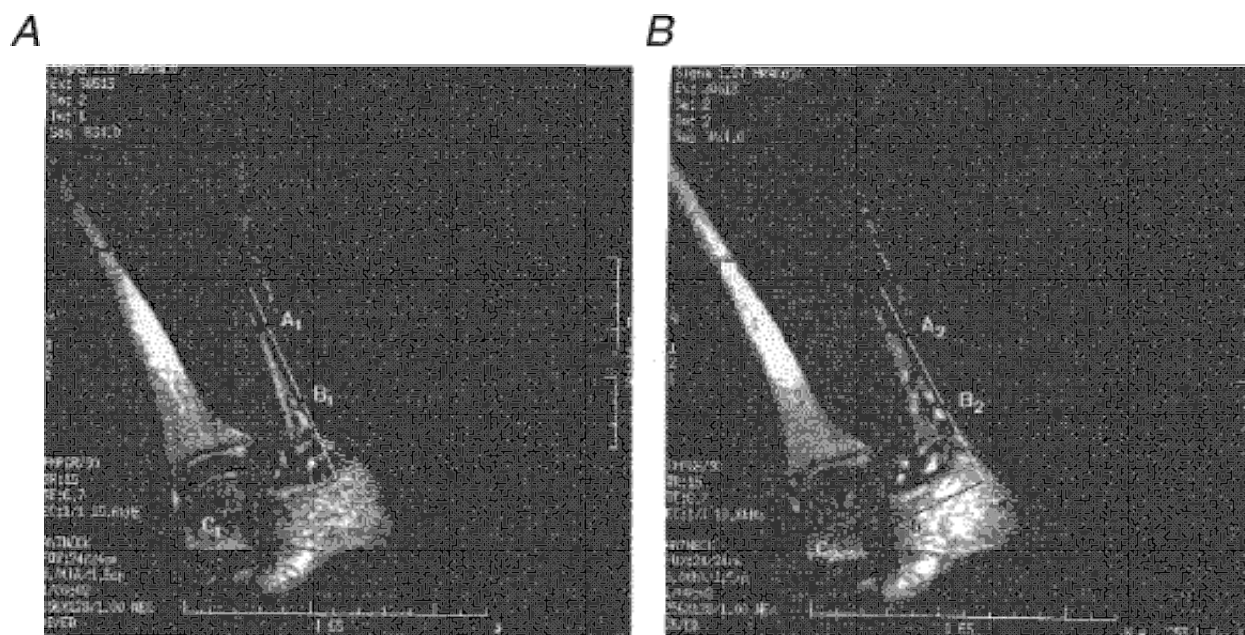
Sagittal MR images of the ankle joint
